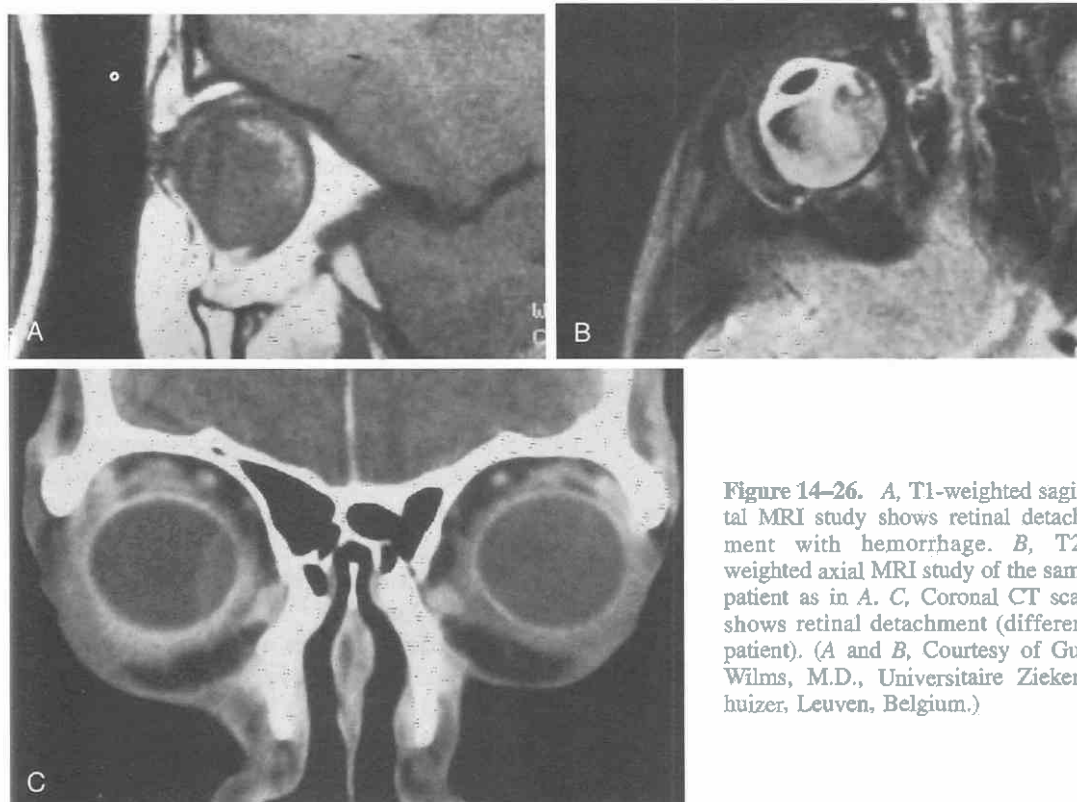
A, T1-weighted sagittal MRI study shows retinal detachment with hemorrhage. B, T2-weighted axial MRI study of the same patient as in A. C, Coronal CT scan shows retinal detachment (different patient). (A and B, Courtesy of Guy Wilms, M.D., Universitaire Ziekenhuizer, Leuven, Belgium.)
